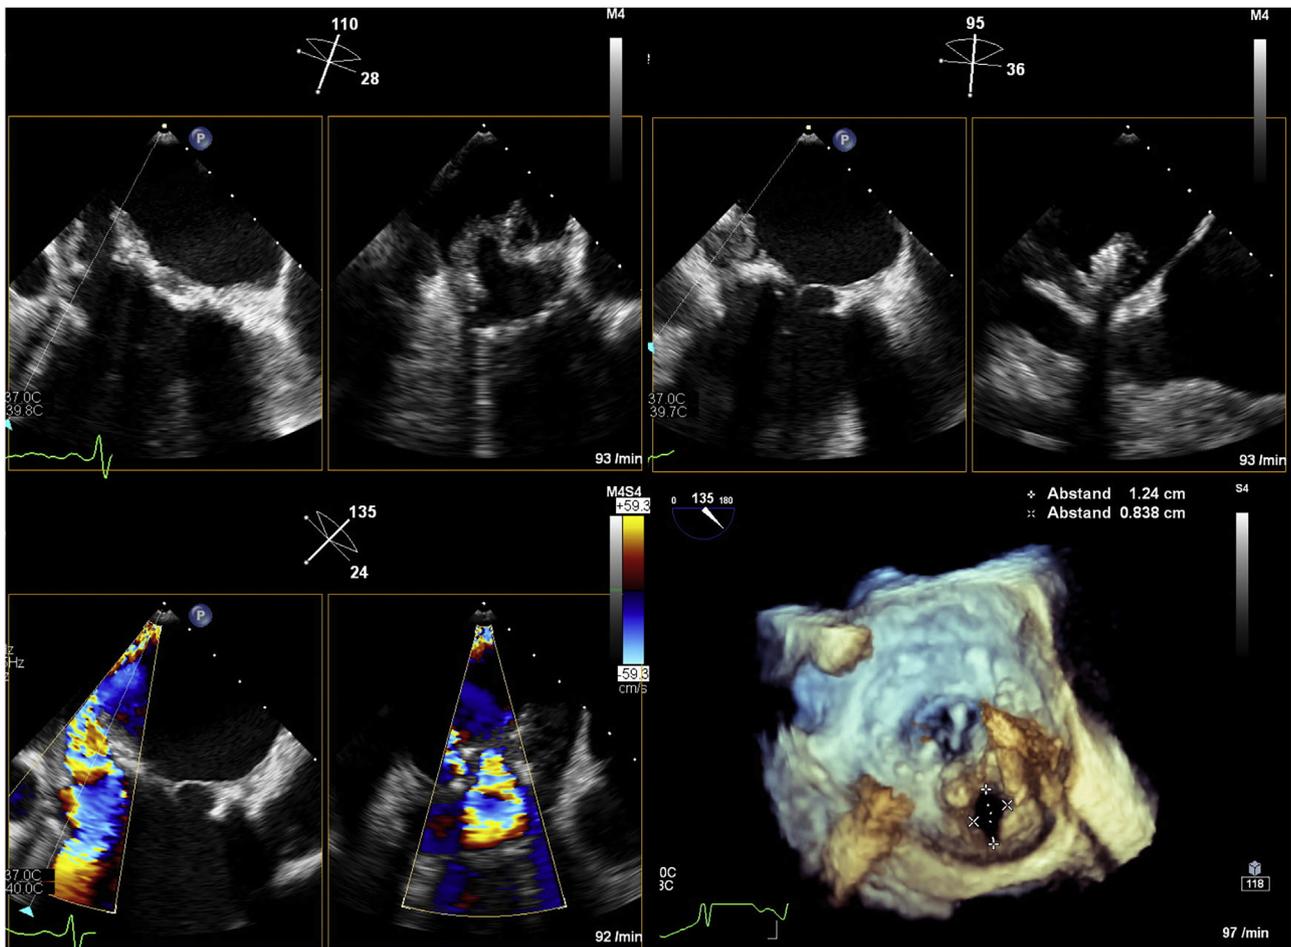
Prosthetic valve endocarditis of the mitral valve with large dehiscence and paravalvular leakage (vegetation with thrombus partly covering large dehiscence) detected by (2D and 3D transesophageal echocardiography).
